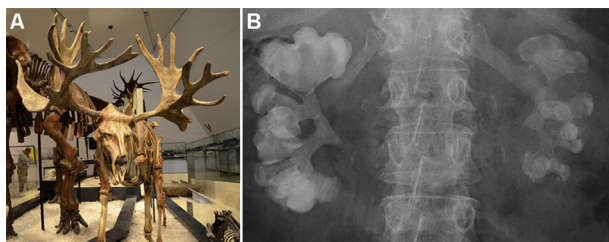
Staghorn. (A) Skeleton of a stag moose, *cervelces scotti*, housed at the Royal Ontario Museum; (B) Plain abdominal X-ray depicting bilateral staghorn calculi.
